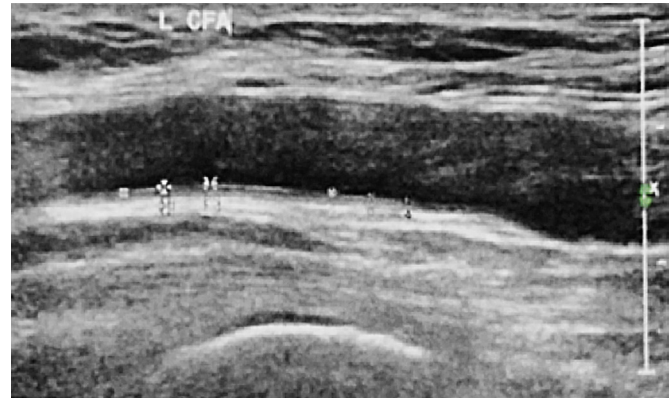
Ultrasonographic evaluation of a patient with Sjögren's syndrome for the identification of intima media thickness (IMT) (arrows), which represents an example of abnormal IMT. Adapted from the personal collection of the authors.
